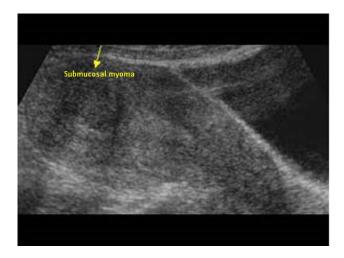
Transvaginal ultrasonography of submucous myoma.
